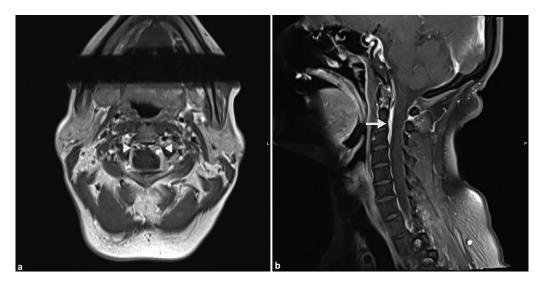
Follow-up cervical spine MRI T1 with contrast 2 days later. (A) Axial section showing near resolution of the enhancing process (arrow heads). (B) Cervical spine MRI with contrast showing smooth anterior epidural enhancement most likely represents prominent venous plexus (arrow).
